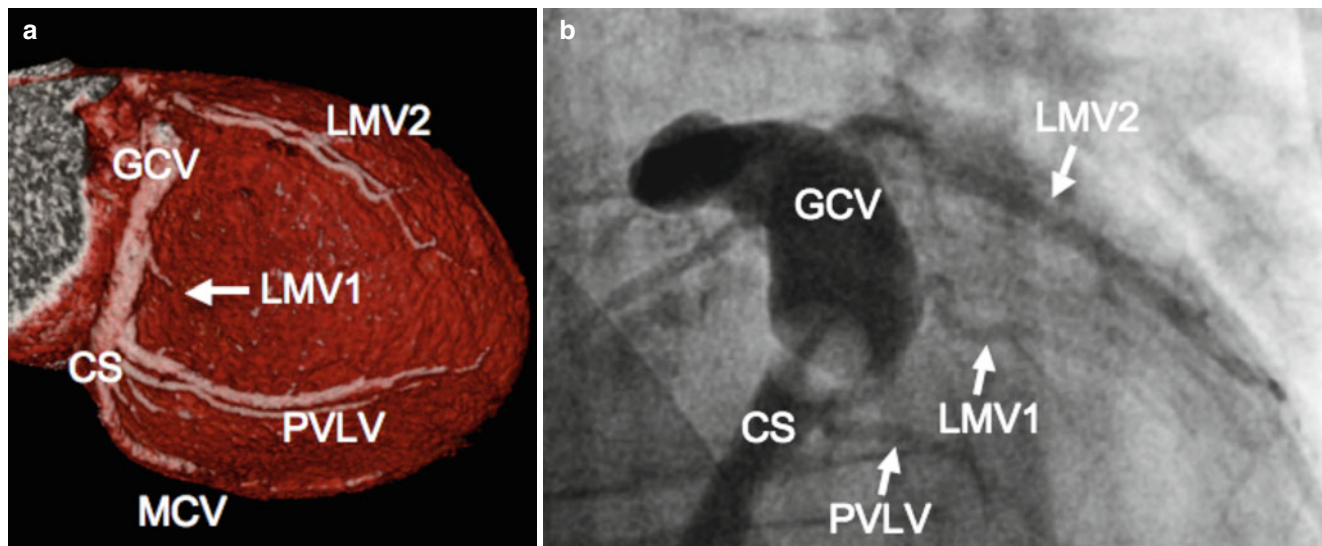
(a) Volume-rendered (VRT) CT image of the coronary venous system using a dedicated coronary venous protocol. (b) Corresponding invasive coronary venography with occlusive balloon-tipped catheter
